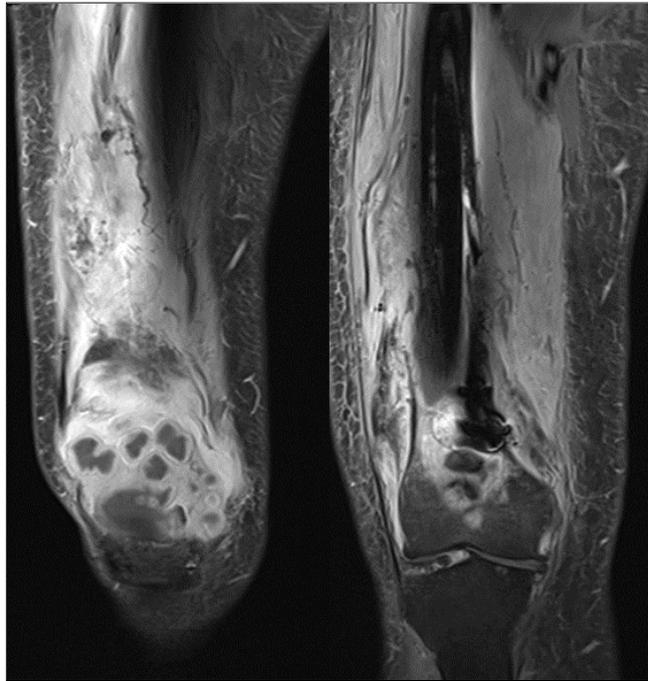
MRI of right knee showing multiple intraarticular bodies and growth of abnormal extraosseous tissue
